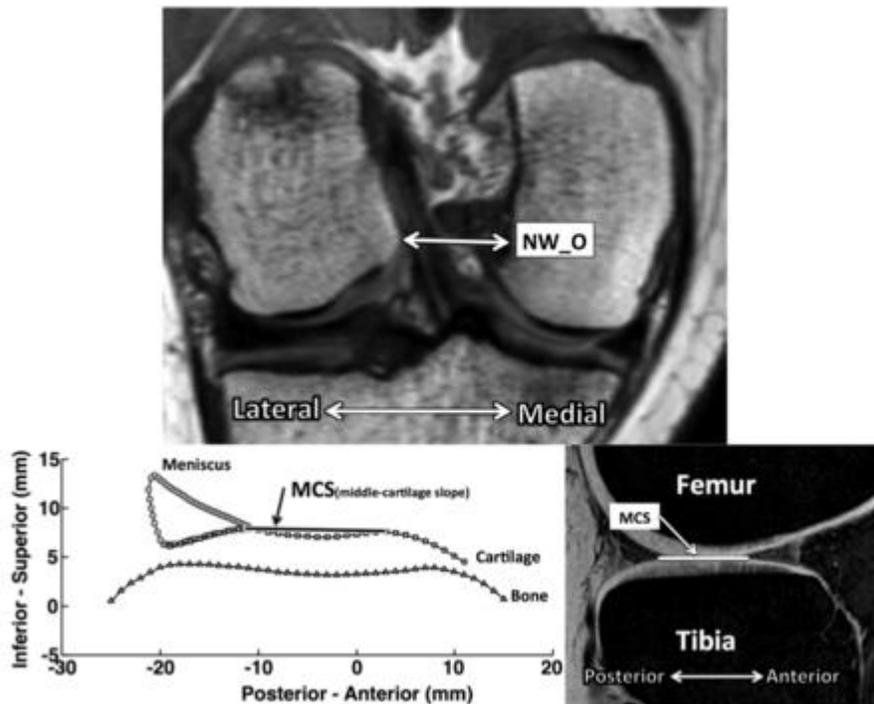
Measures most predictive of risk in females: the femoral intercondylar notch width at the anterior outlet of the anterior cruciate ligament (NW_O, top) and tibial plateau (Tib) lateral compartment (L_{at}) middle region articular cartilage slope (MCS) displayed relative to postprocessed articular cartilage surface data (lower left) and in relation to MRI sagittal-plane image (lower right). Decreased notch width at its anterior outlet and increased lateral compartment middle cartilage slope were best associated with increased ACL injury risk in females.
